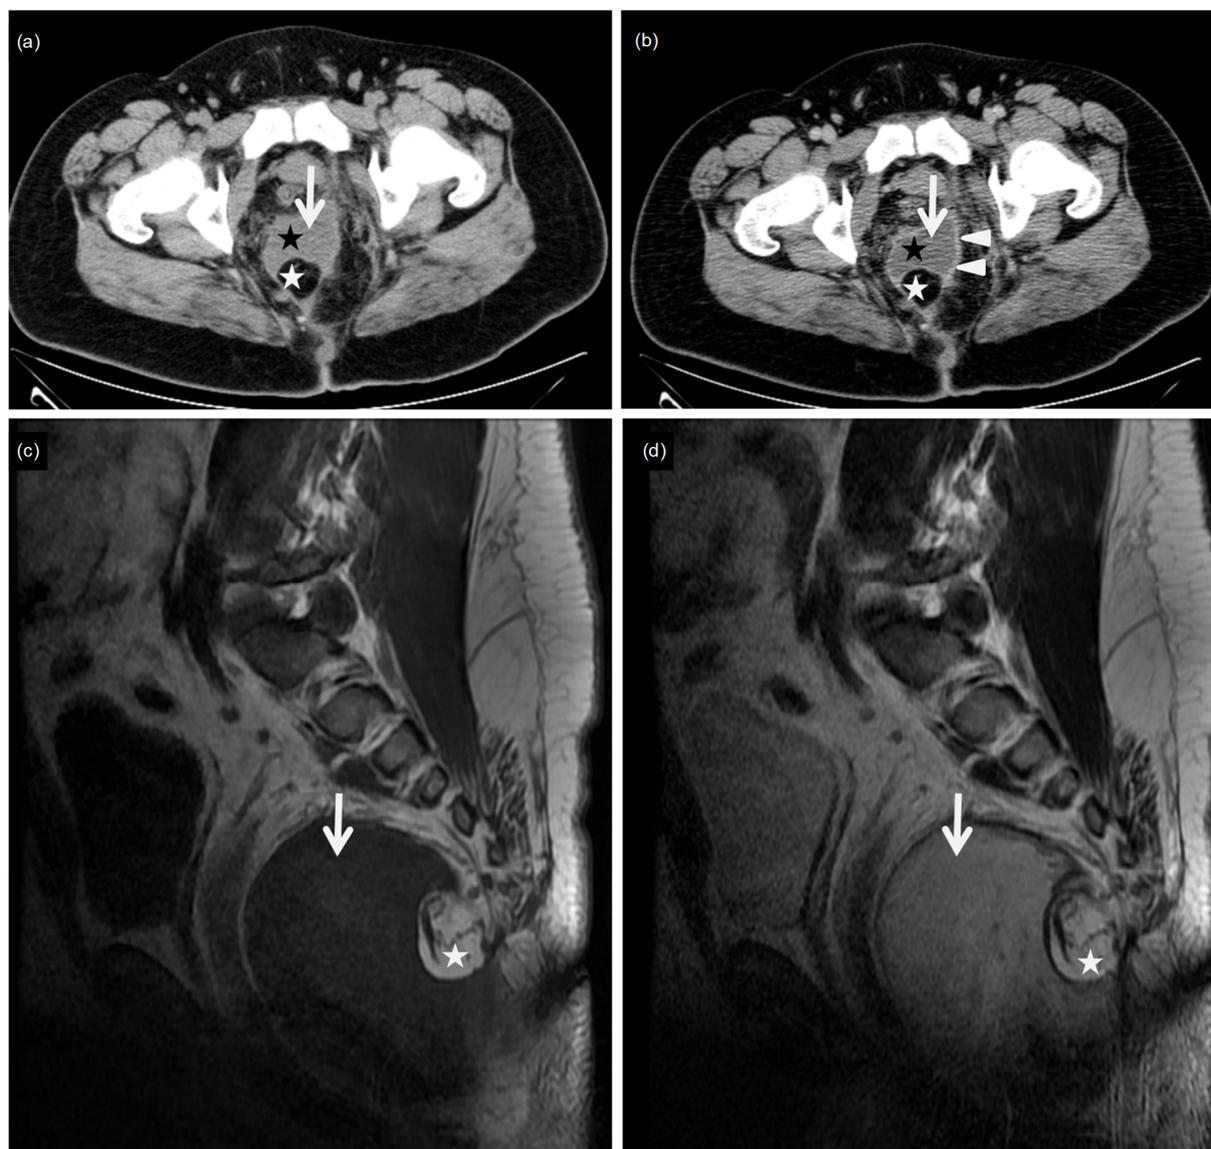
Pelvic CT and MRI images of a 21-year-old male patient with a benign mature SCT
